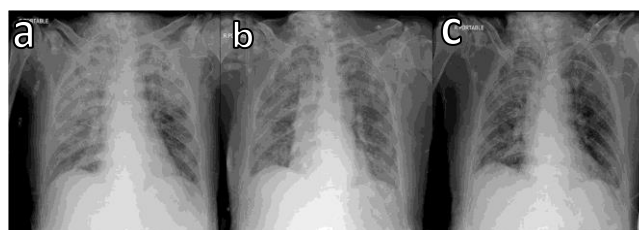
Chest radiography after methylprednisolone administration. Chest radiography on day 16 (A), chest radiography on day 18 (B), chest radiography on 20 (C)
